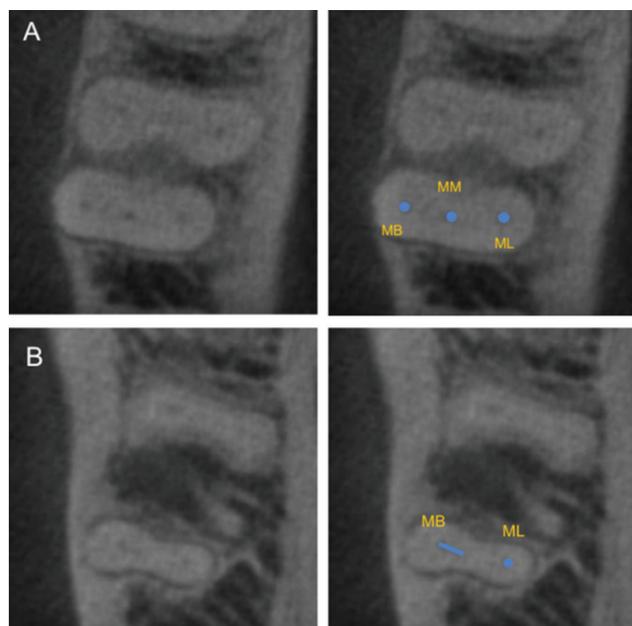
CBCT images of middle mesial canal that was confluent type: (A) Middle mesial canal at 1 mm below the orifice level. (B) Middle mesial canal joined with mesiobuccal canal at the 7 mm below orifice level. MB, mesiobuccal; MM, middle mesial; ML, mesiolingual.
